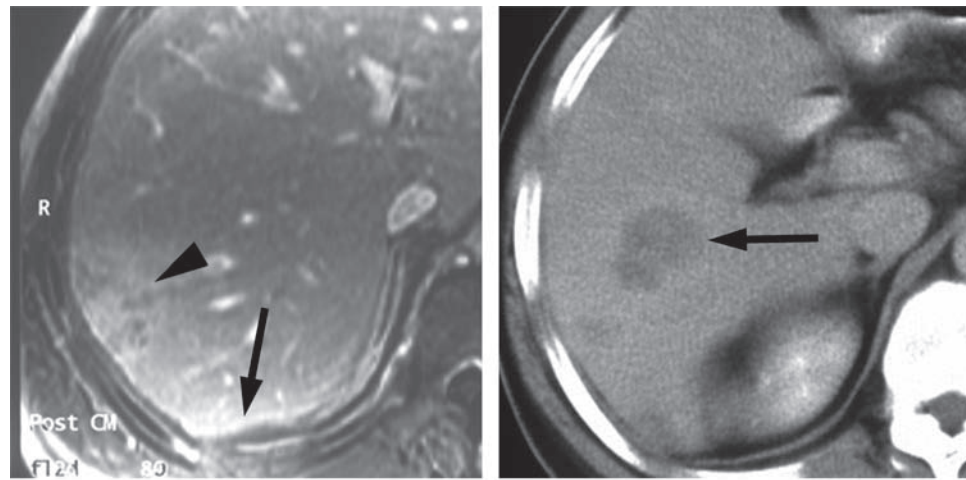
Fascioliasis of the liver in a 49-year-old man. (a) Gadolinium-enhanced gradient-echo T1-weighted MR image (repetition time msec/echo time msec = 160/4, 80° flip angle) shows a heterogeneously enhancing lesion (arrowhead) and capsular enhancement (arrow). (b) On a contrast-enhanced CT scan obtained 21 days later, the lesion has migrated toward the center of the liver and contains a cluster of microabscesses with a track-like appearance (arrow).
